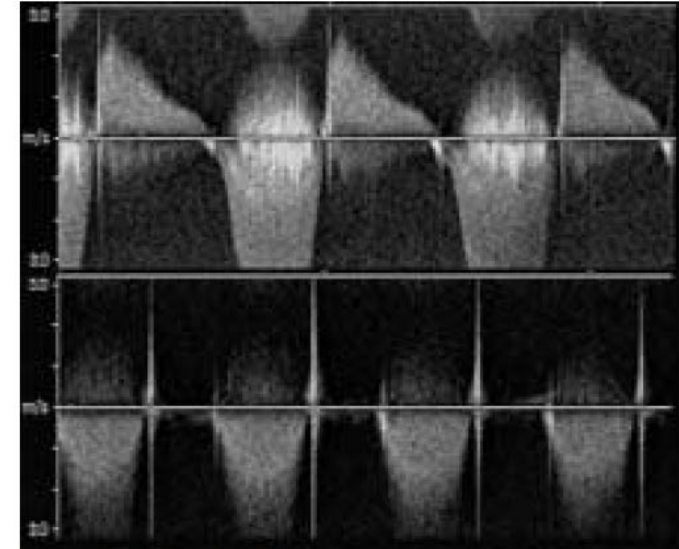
Doppler imaging
